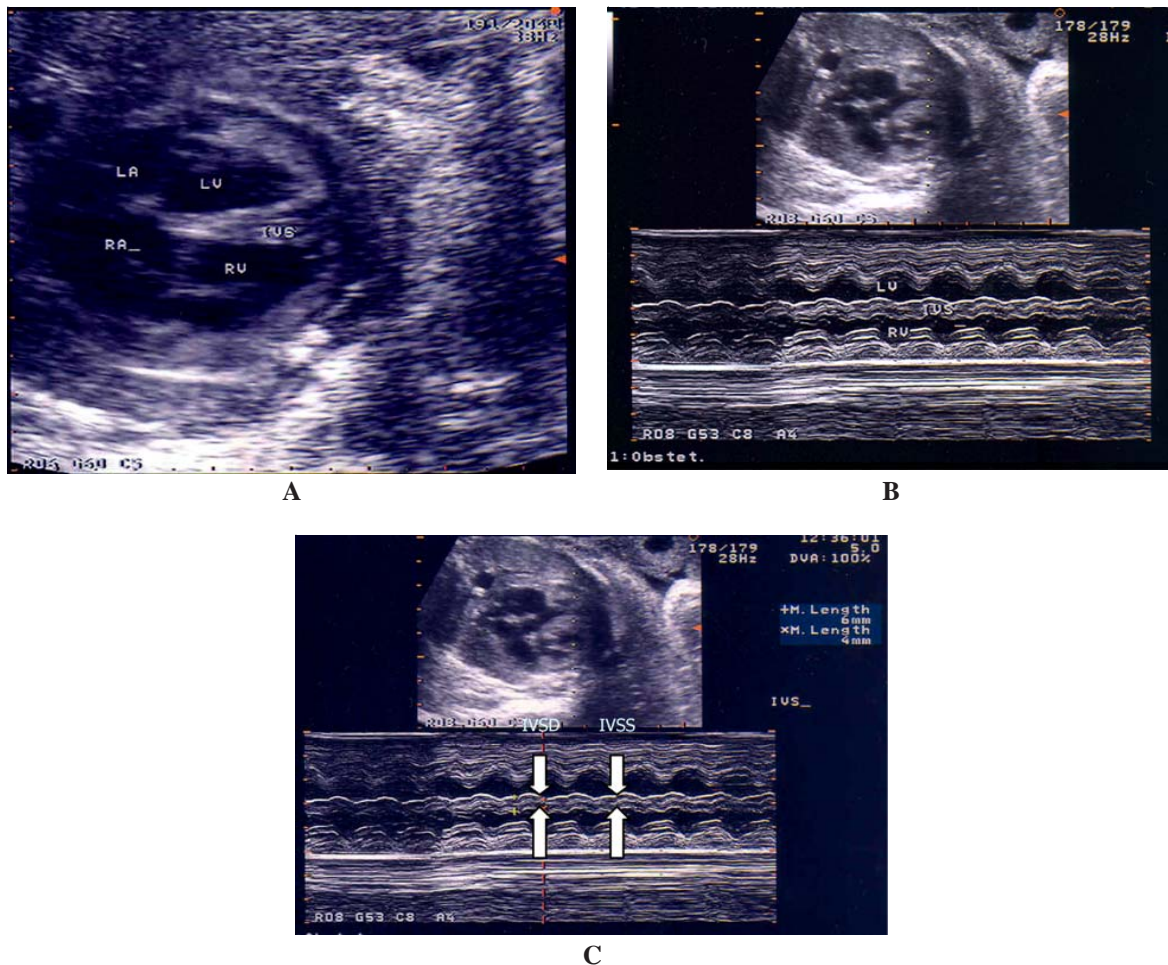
The interventricular septal thickness: (A) 4-chamber view (B) Interventricular septum by M-mode echocardiography (C) The measurement of interventricular septal thickness during diastole and systole: the distance between the outer edge of each margin was measured in millimeter. (IVS: interventricular septum; IVSD: interventricular septal thickness during diastole; IVSS: interventricular septal thickness during systole; LA: left atrium; LV: left ventricle; RA: right atrium; RV: right ventricle)
